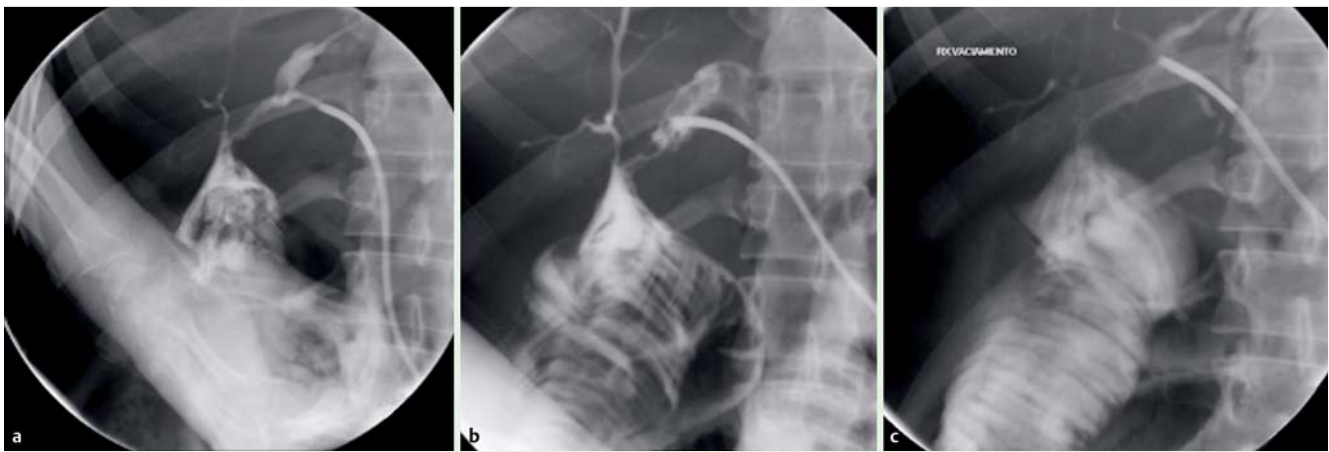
Radiographic images showing: a cholangiography being performed with the SpyGlass system; b the SpyGlass in position in the left intrahepatic duct during laser application; c no evidence of intrahepatic lithiasis following laser lithotripsy and extraction of the stone fragments.
